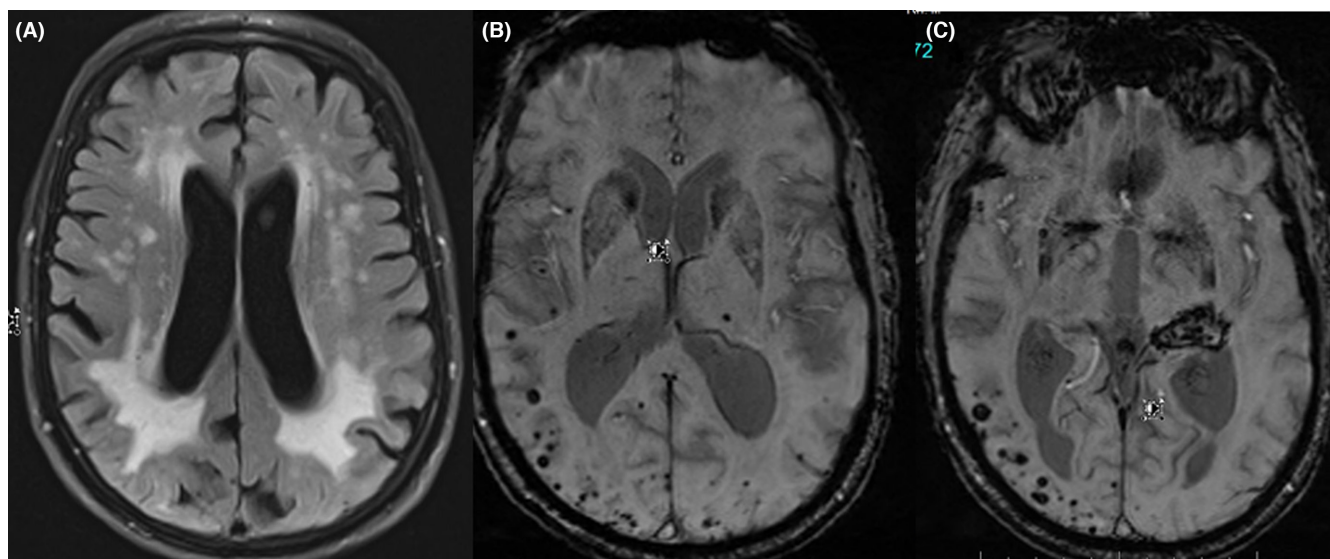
Cerebral magnetic resonance imaging showing global atrophy, leukoaraiosis, periventricular T2 hyperintense spots (A), subcortical microbleeds (B), and bleeding in the left thalamus (C). These findings were consistent with the diagnosis “probable cerebral amyloid angiopathy” according to the modified Boston criteria.⁶
